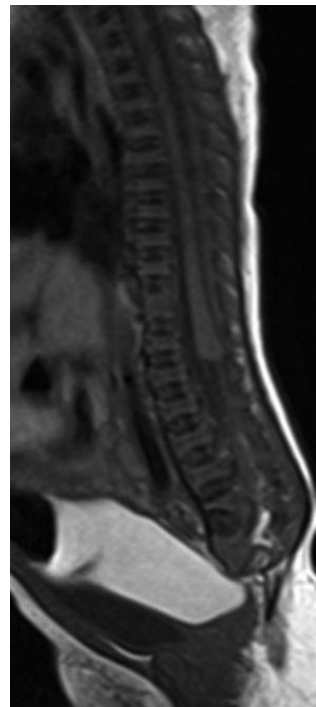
Sagittal T1-weighted MRI of lower neonatal spine shows dysmorphic conus medullaris and absence of sacrum and coccyx. (TSE T1, TR, 601; TE 12)
